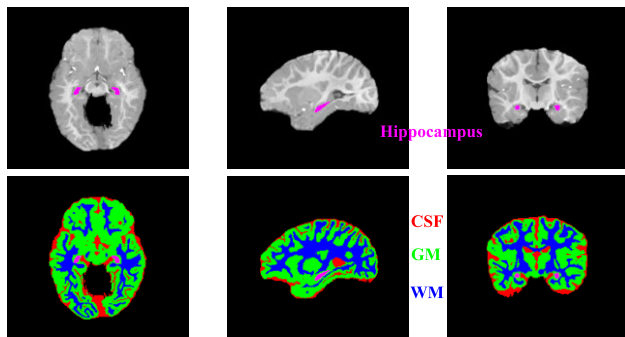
Slices of infant brain MR images and four labels: CSF, GM, WM and hippocampus.
